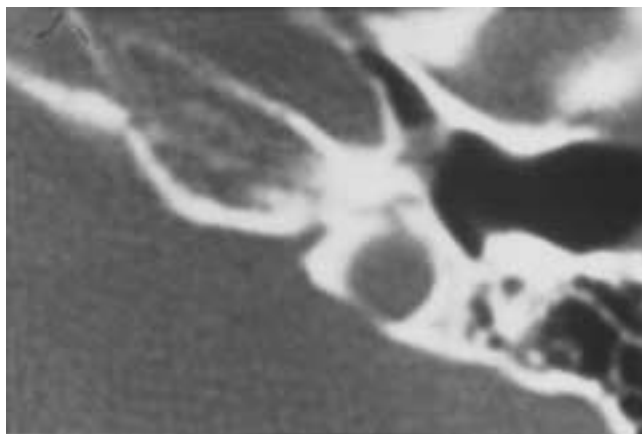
Small glomus tympanicum tumor. Axial CT. This otoscopically circumferentially visible tumor, corresponding to Fisch type A, is removable by the transmeatal approach. Angiography is not necessary.
